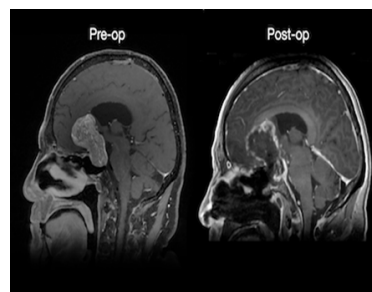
MRI brain preoperatively & post operatively
